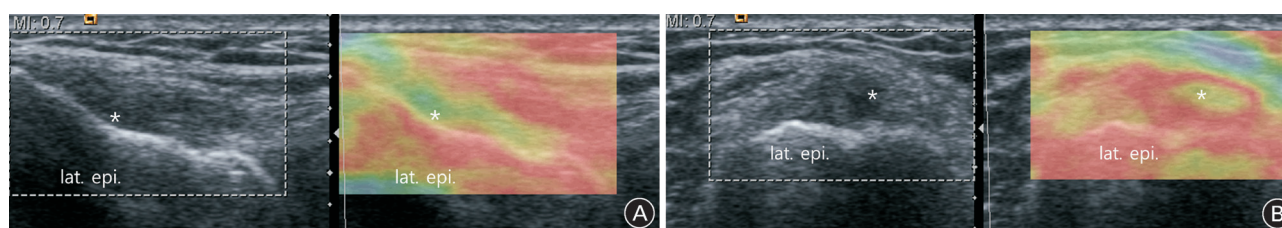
Greyscale ultrasonographic and sonoelastographic images showing tendinosis of the common extensor tendon in a 48-year-old housewife (A: longitudinal view; B: transverse view). The ultrasonographic images (left) depict areas of softening (asterisks; sonoelastographic score 2 (mostly soft)); note the green-to-yellow contrast to the surrounding red area in the sonoelastographic images (right). lat. epi.=lateral epicondyle.
